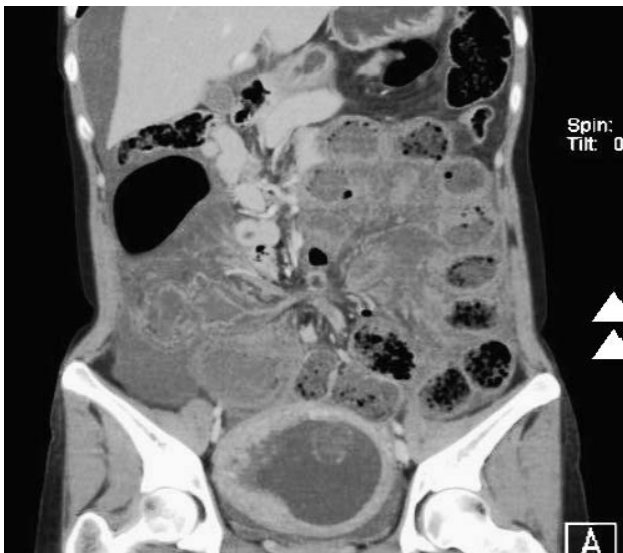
(b) Contrast-enhanced CT scan (coronal view) shows distended sigmoid colon (white arrowhead).
